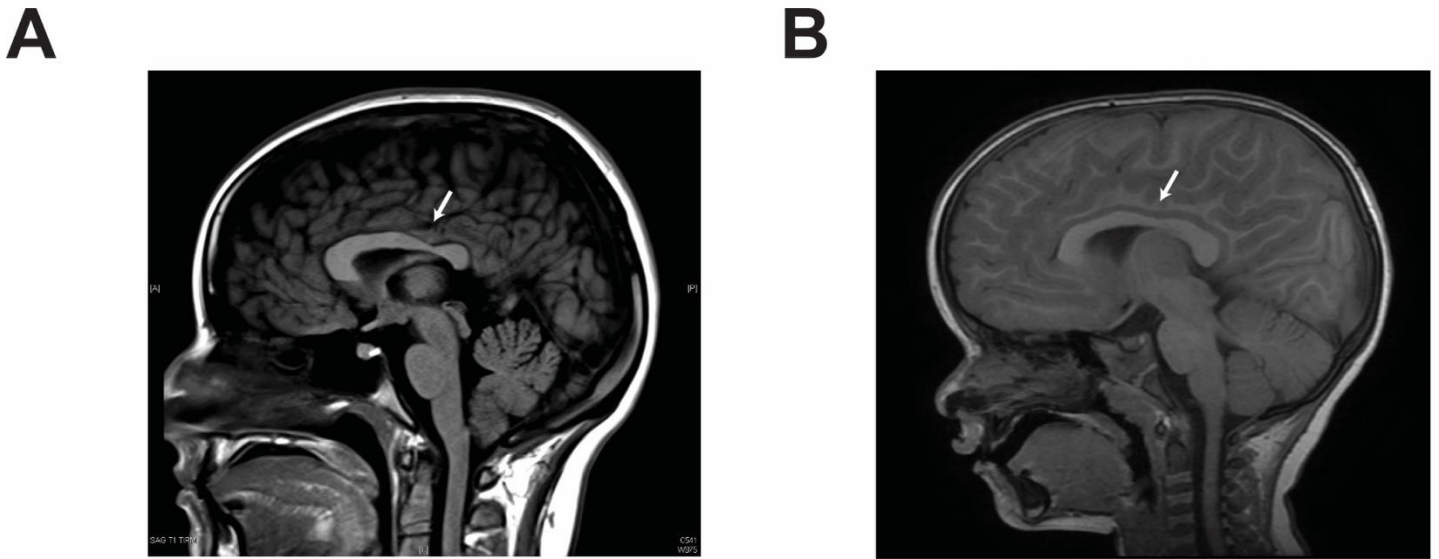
MRI images from individuals 10 and 11. Arrows indicating dysgenesis of corpus callosum in individual 11 (A) and possible corpus callosum abnormality (upper limit of normal) in individual 10 (B).
